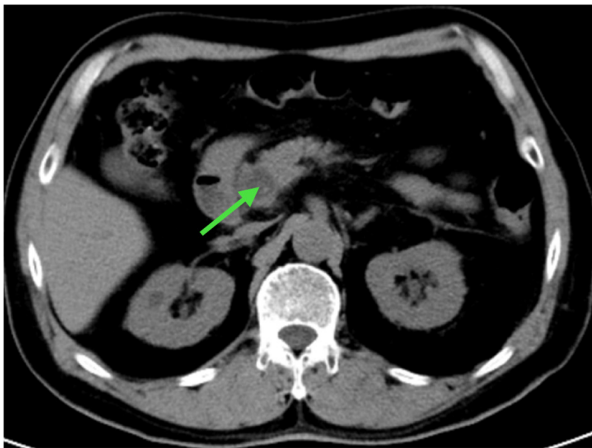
Abdominal computed tomography scan showing an oval low-density shadow on the head of the pancreas, ~19x22 mm in size, with clear edges and an heterogenous internal texture (arrow).
